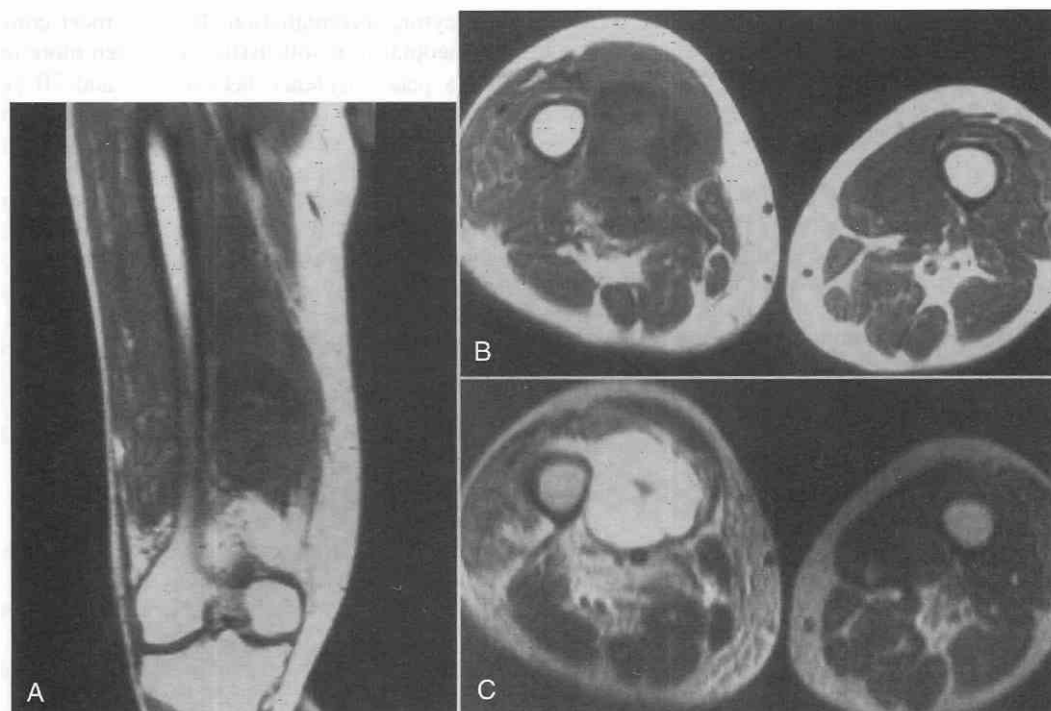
Malignant fibrous histiocytoma in the medial compartment of the thigh. A and B, Coronal T1-weighted spin-echo image (TR = 600 msec, TE = 15 msec) (A) and axial T1-weighted spin-echo image (TR = 700 msec, TE = 15 msec) (B) reveal a large mass reflecting low signal intensity. C, Axial T2-weighted spin-echo image (TR = 2500 msec, TE = 80 msec) demonstrates that the mass has heterogeneous high signal intensity.
